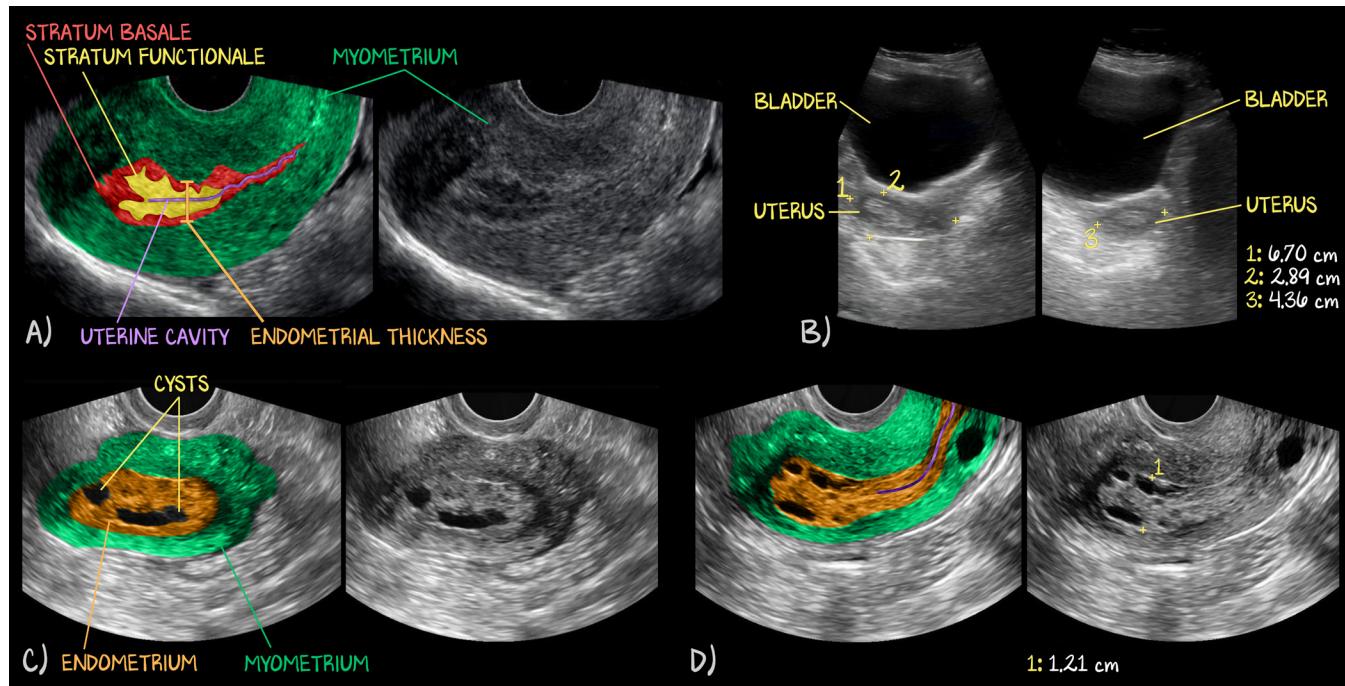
Sonographic Endometrial Hyperplasia
